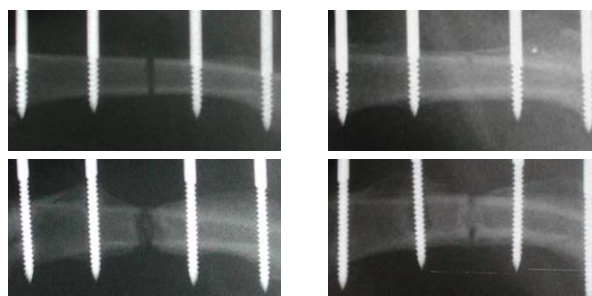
X-rays of osteotomised femur at 56 days. Top: directly post OP (left) and sham (right); Bottom: atrophic non-union (left) and MSC treated (right).
